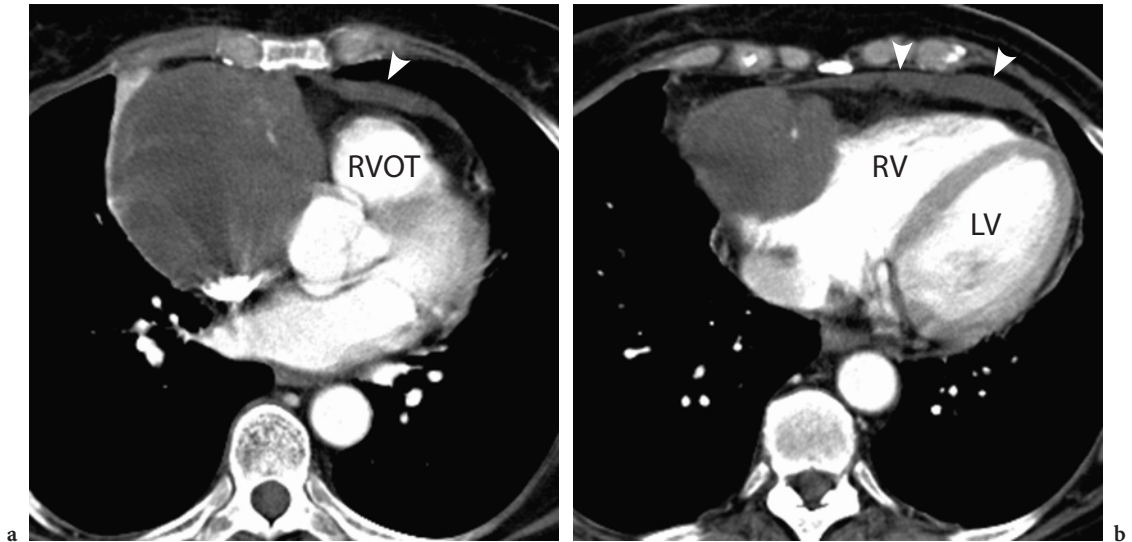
Patient with a very large angiosarcoma arising from the right atrium, examined with 16-slice CT. The cardiac anatomy is displayed in two axial levels (a, b). The mass already invades the pericardial sac, as evidenced by pericardial effusion (*arrowheads*). *RVOT* Right ventricular outflow tract
